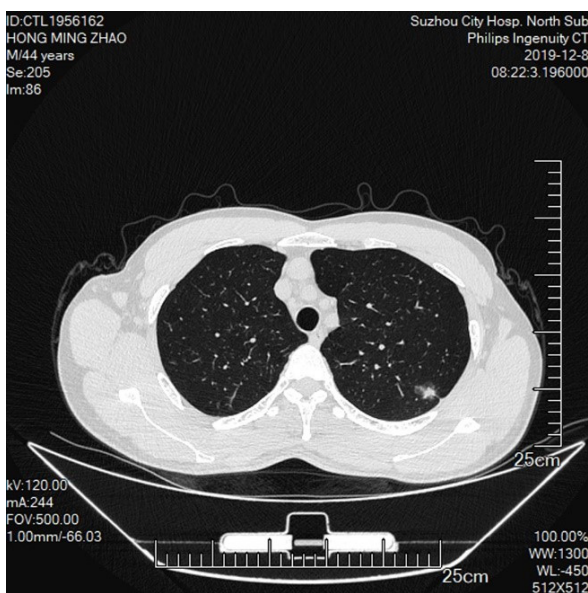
35 cases were cluster signs which were indicated by CT.
